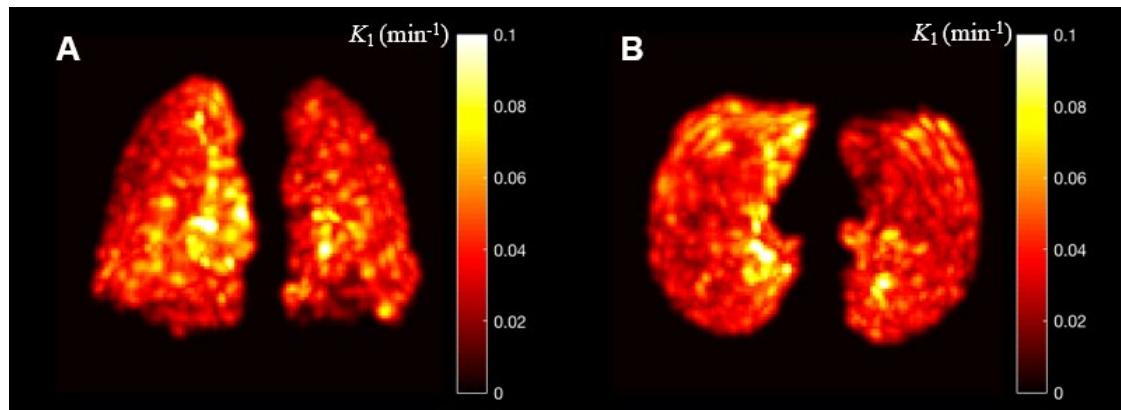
Parametric images of lung FDG K_1 of a healthy subject on the coronal plane (A) and transverse plane (B). Shown are maximum intensity projection images.
